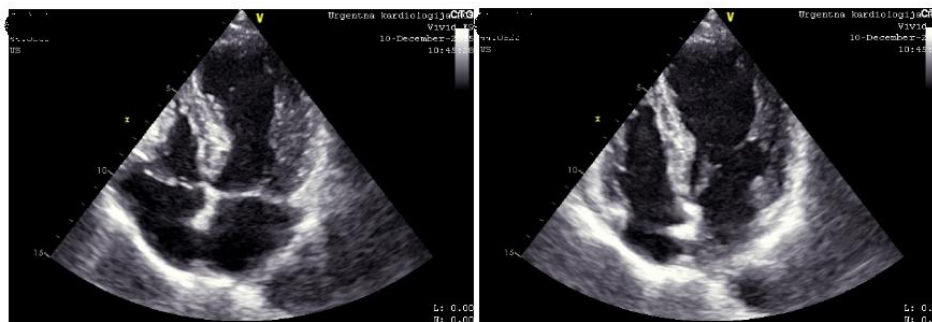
Apical 4-chamber view showing apical ballooning during acute phase.
